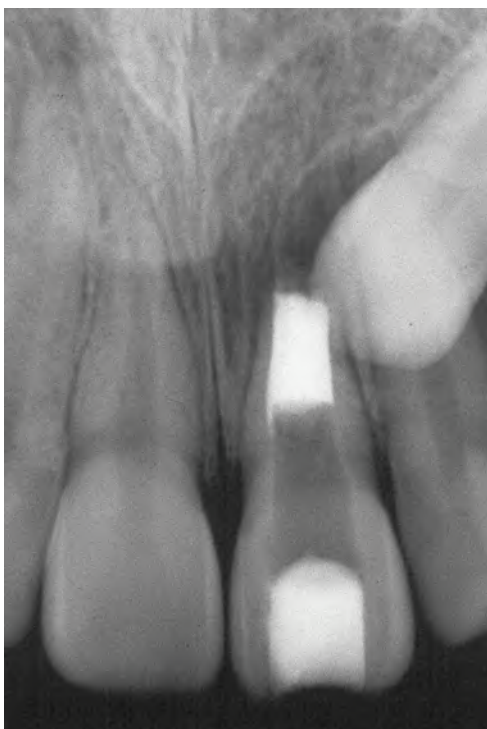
Radiographic image of maxillary left central incisor demonstrating placement of a 3- to 5-mm thickness of MTA. (Courtesy of Dr. Marshall E. Gomes, Lodi, CA, U.S.A.)
